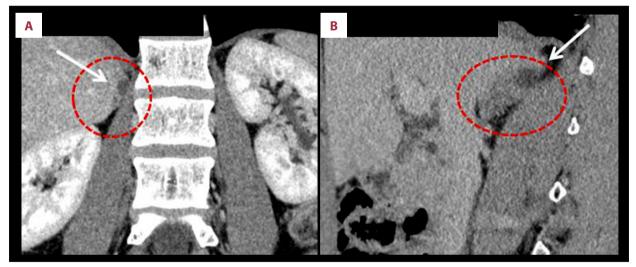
Preoperative enhanced computed tomography (CT) imaging of the right adrenal adenoma in a 44-year-old man with primary aldosteronism. (A) (Coronal enhanced CT) Coronal view of the preoperative enhanced computed tomography (CT) image shows a right adrenal mass, indicated by arrows. (B) (Sagittal enhanced CT) Sagittal view of the preoperative enhanced CT shows a 12 mm mass in the posterior part of the right adrenal gland, indicated by arrows.
